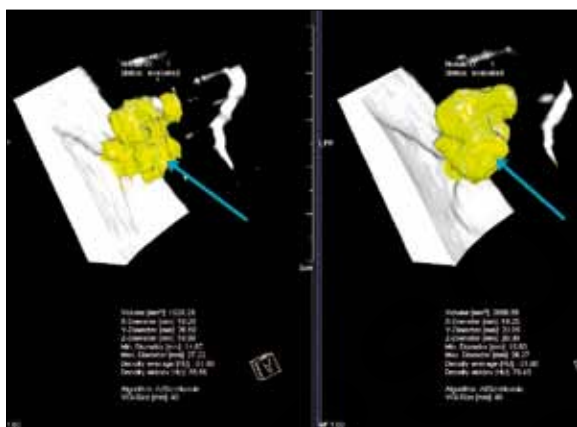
The image of a 72 year old man. Fast growing peripheral cancer of the lung. CT of the chest. Applied software – LungCARE (Siemens) for construction of the 3D models of the lesion, calculations of its sizes and volume. At the left – the first scan, on the right – repeated investigation in 2 months later. Tumor has increased in volume from 1929 mm³ to 2686 mm³ (see the arrow).
